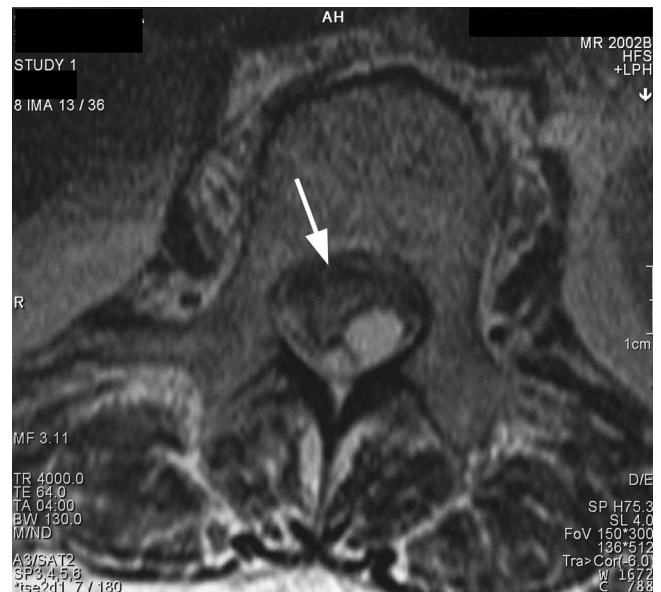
T2 axial magnetic resonance image showing the hematoma (L2).
